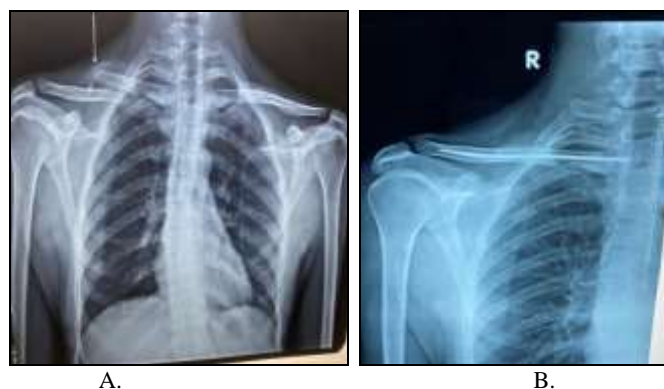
a) Preoperative radiograph of a 32 yr old manual labourer. b) Follow up radiograph at 6th month.
